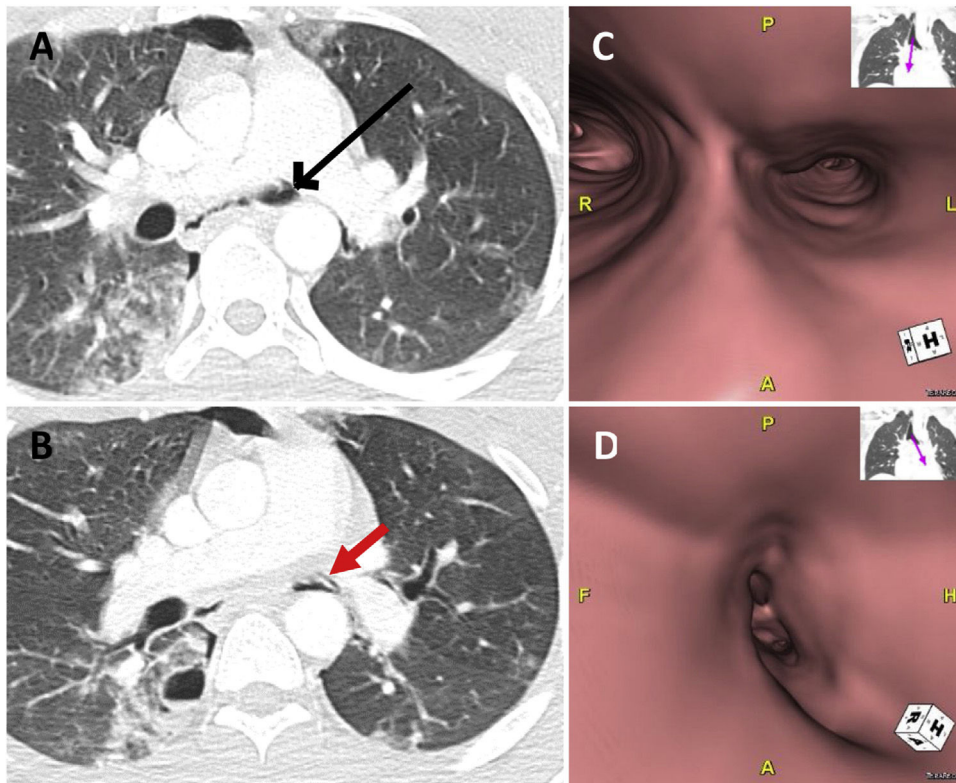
Rupture of the left main bronchus in a 19-year-old patient involved in a motorcycle accident. A and B) Axial chest CT images (lung window) showing an irregularity and small loss of continuity in the wall of the left main bronchus (thick arrow in A), partially collapsed, as well as a small pneumomediastinum (thin arrow in B). C and D) 3D reconstructions (virtual bronchoscopy) showing the collapsed bronchial lumen (conventional fibrobronchoscopy confirmed the suspicion of bronchial rupture). The patient underwent a left pneumonectomy after an unsuccessful attempt to repair the bronchial rupture.
